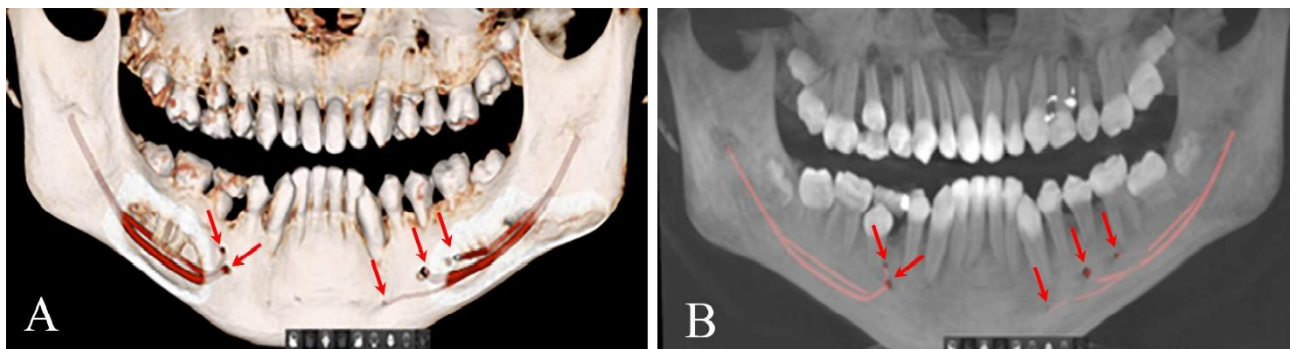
A) 3D reconstruction model of bifid on the right side and trifide on the left side of the mandibular canal structure, bone image; B) 3D reconstruction model of bifide on the right side and trifide on the left side of the mandibular canal structure, X-ray image.
